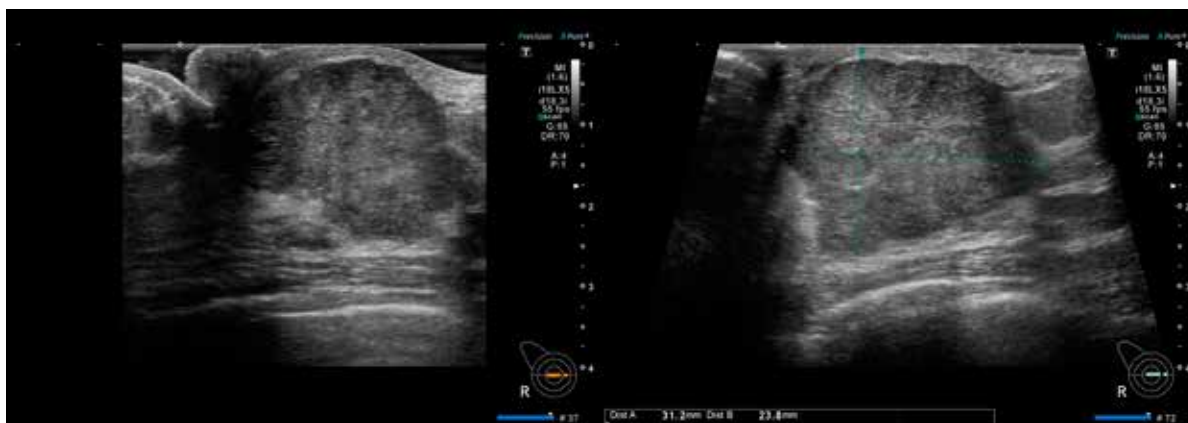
Breast ultrasonography revealed a hypoechoic mass, 31 mm in diameter, in the EAB region of the right breast.
